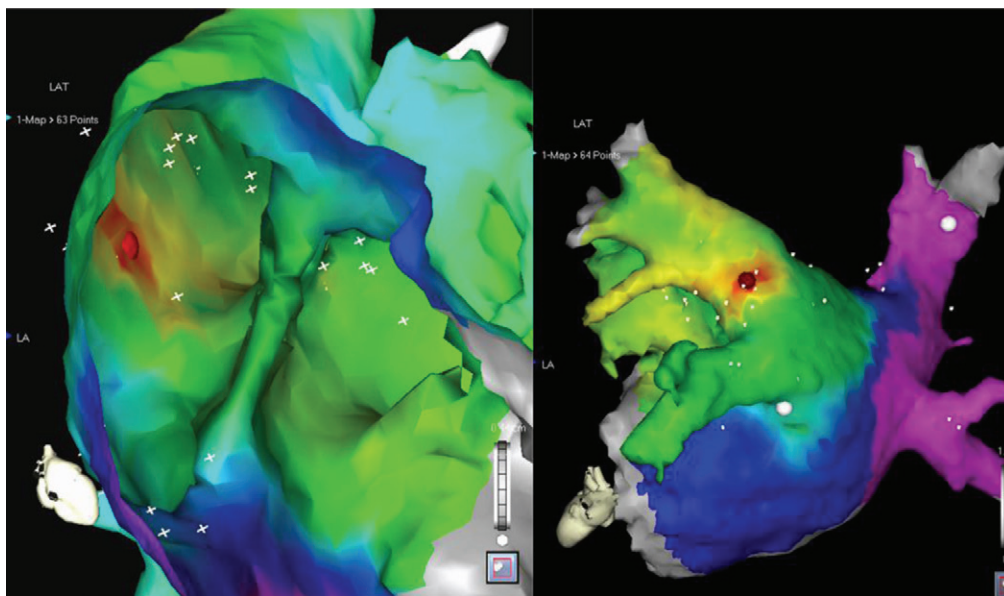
Example of activation map of focal atrial tachycardia arising from left superior pulmonary vein using CARTO three-dimensional mapping system integrated with computed tomography scan. *Left panel* shows the internal “cut-out” view. *Right panel* shows the view of the posterior atrium. Activation timing is color coded, with early sites in red and late sites in purple. Centrifugal activation is seen from the left superior pulmonary vein; ablation was successful at this site (red dot).
